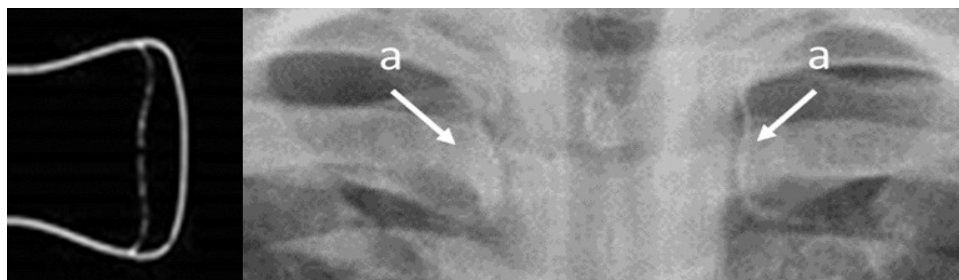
Radiograph of a 25-year-old patient showing stage 4 ossification: the estimated age = 27 years.
